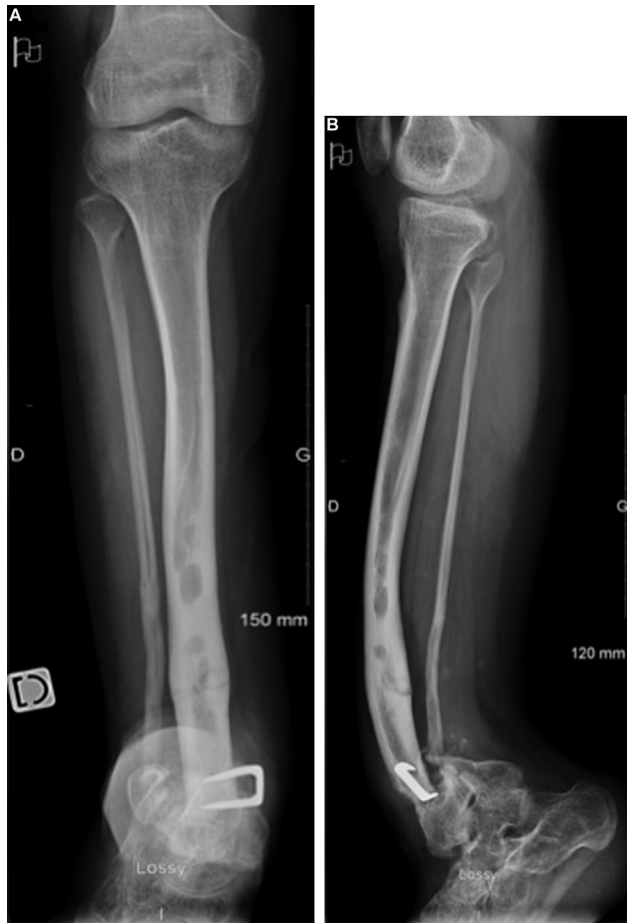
Initial radiographs showing dystrophy of the tibia and fibula with anterolateral bowing; note the staple and evidence of pseudarthrosis of the tibia and fibula.
